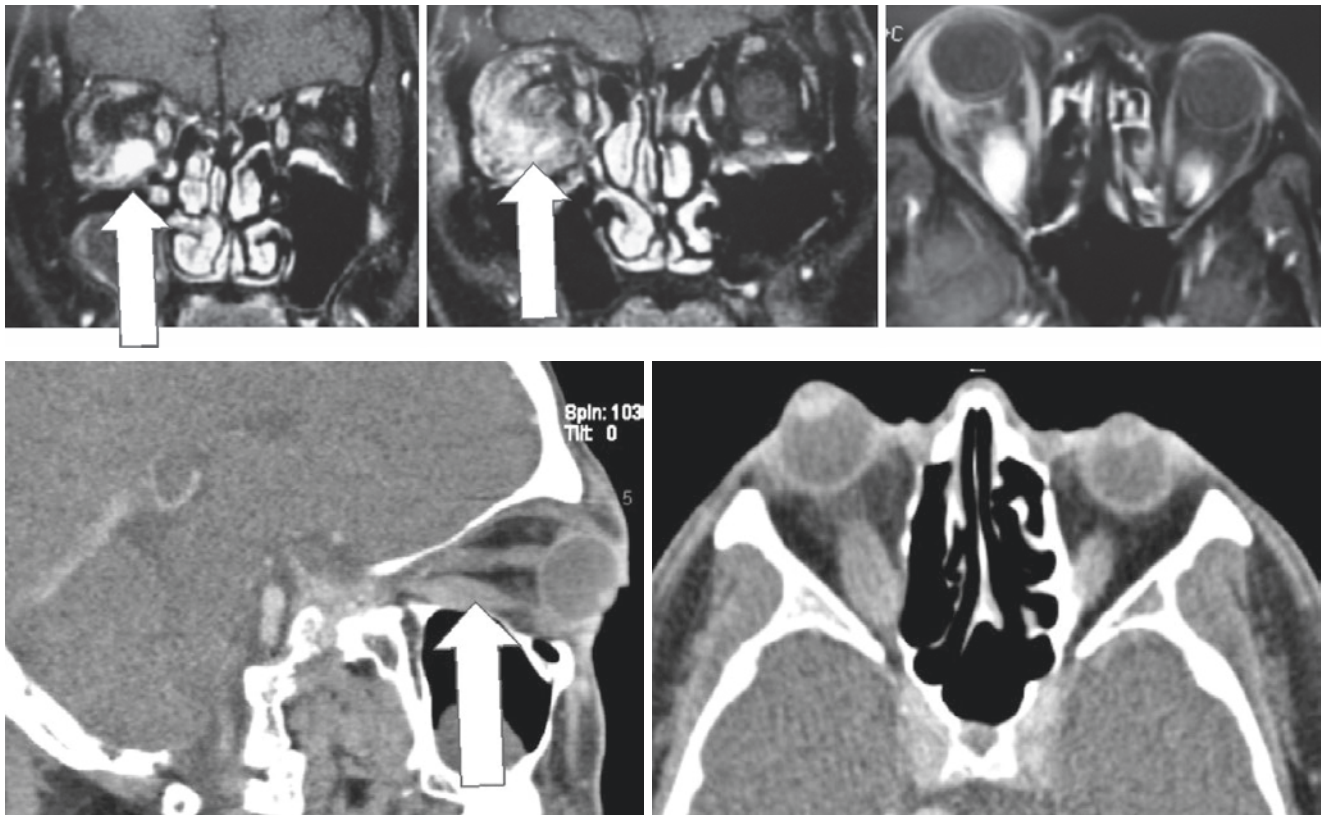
Clockwise from the top left: coronal T1w MRI with contrast shows enlarged enhancing right inferior rectus muscle (arrow). Coronal T1w MRI with contrast showing diffuse enhancement of right intraconal fat (arrow). Axial T1w MRI with contrast shows enlarged right inferior
